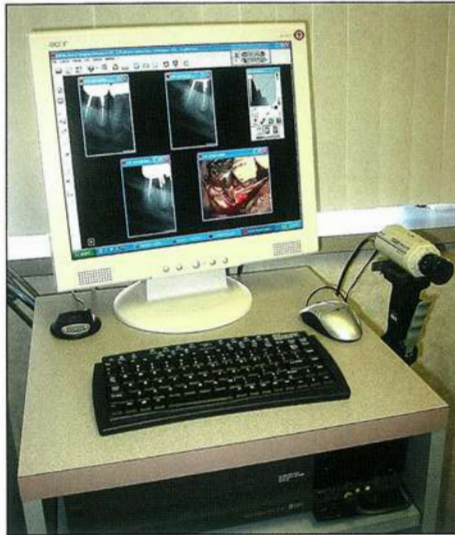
Digital radiographs and clinical images on a 19-inch flat-panel LCD screen.
